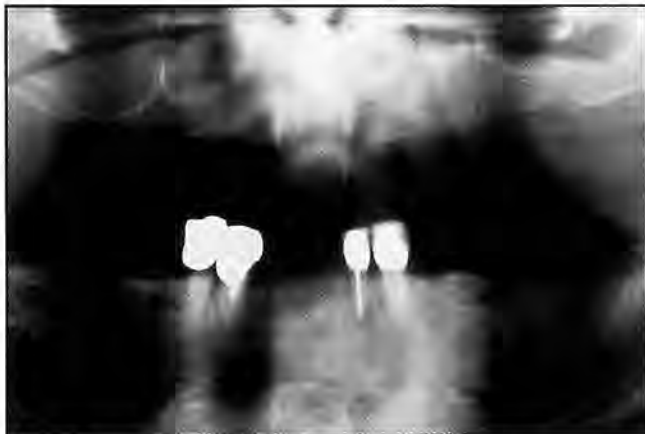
Panoramic radiograph for case type I. Remaining teeth #21, #22, #27, and #28 were diagnosed as hopeless and extracted.
